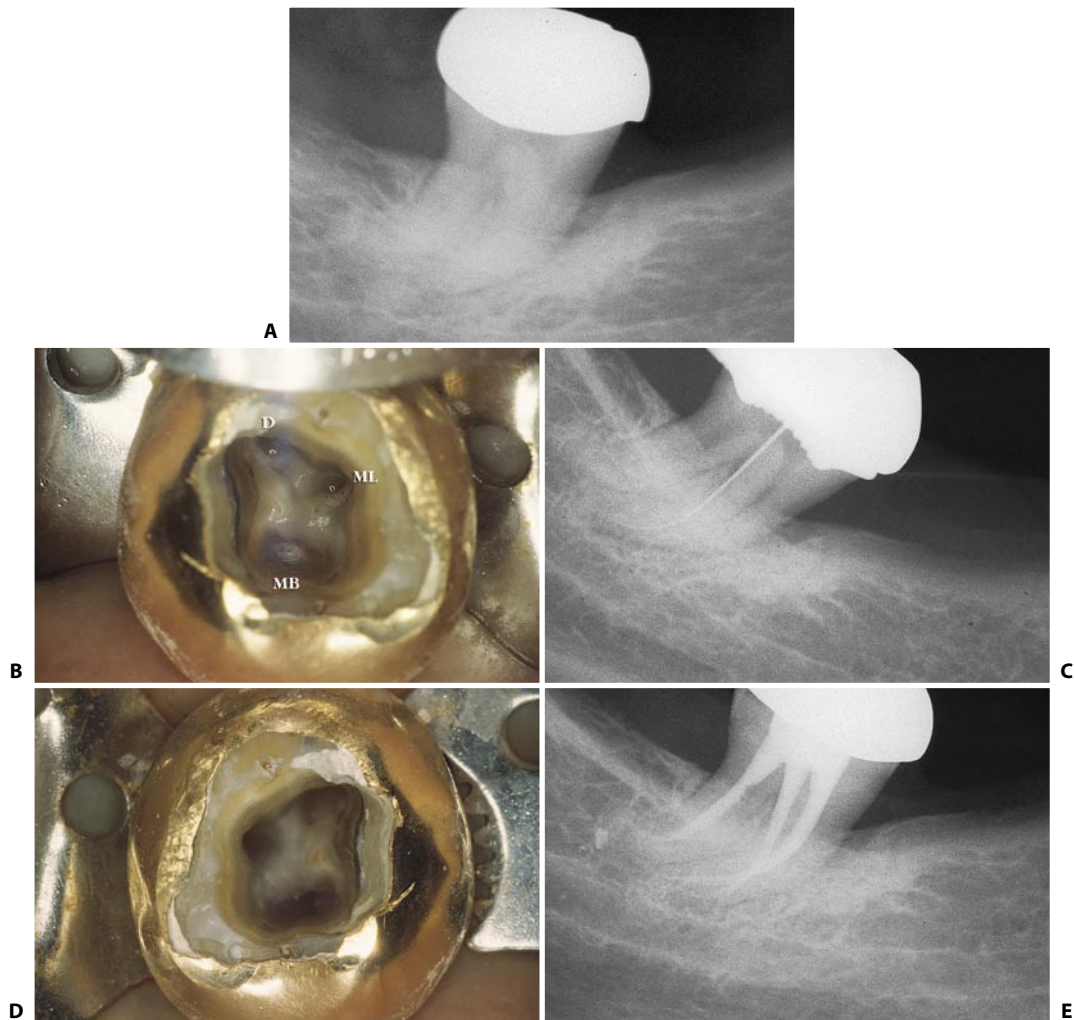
A lower second molar with the three classical canals oriented a bit unusually: the mesiolingual canal is close to the distal canal. A. Preoperative radiograph. B. Access cavity: the opening of the mesiolingual canal is very close to that of the distal canal, so much so that it resembles a distolingual canal. D, distal canal; ML, mesiolingual canal; MB, mesiobuccal canal. C. Intraoperative radiograph demonstrating the course of the mesiolingual canal. D. Access cavity showing cleaned and shaped root canals. E. Postoperative radiograph.
